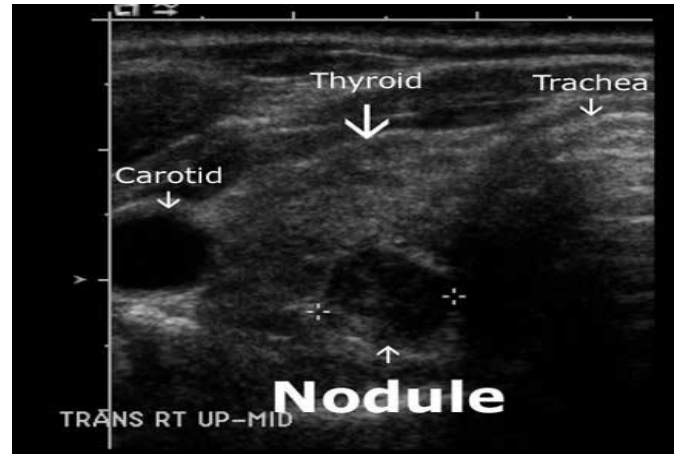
Thyroid Ultrasound Image [13]
